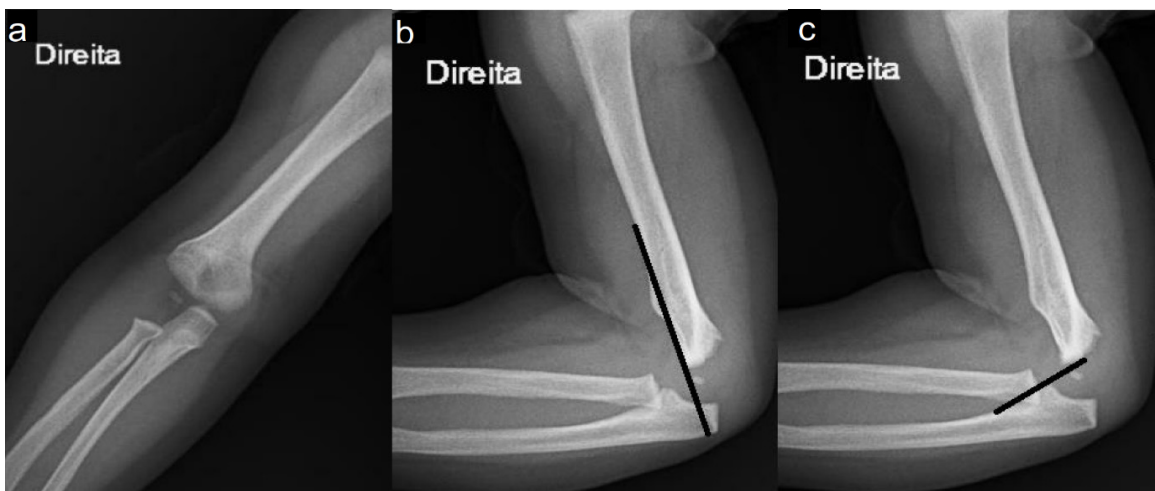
Postoperative radiograph of the right upper limb in an 8-month-old infant. Antero-posterior (A) and profile (B and C) views showing joint congruence, making it possible to visualize the line drawn in the humerus anterior cortex and the line drawn parallel to the radius crossing the capitulum
